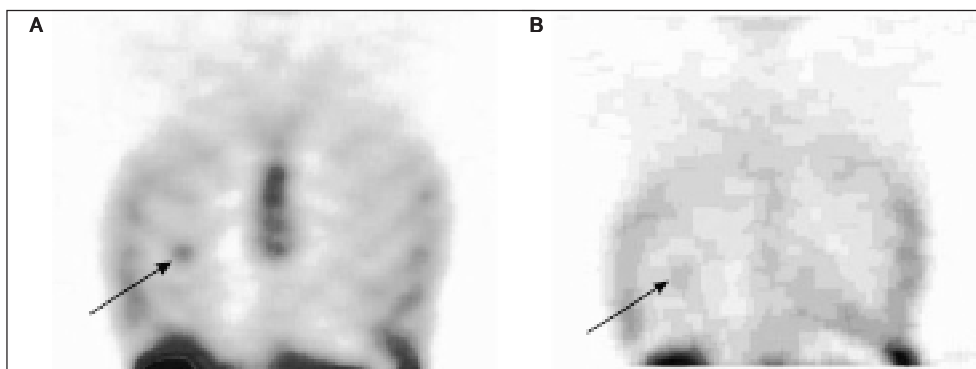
An example of positive ^{99m}Tc -depreotide scintigram of a benign nodule of unknown etiology (it resolved during a 6 month observation period); B. Equivocal ^{99m}Tc -EDDA/HYNIC-TOC scintigram.
